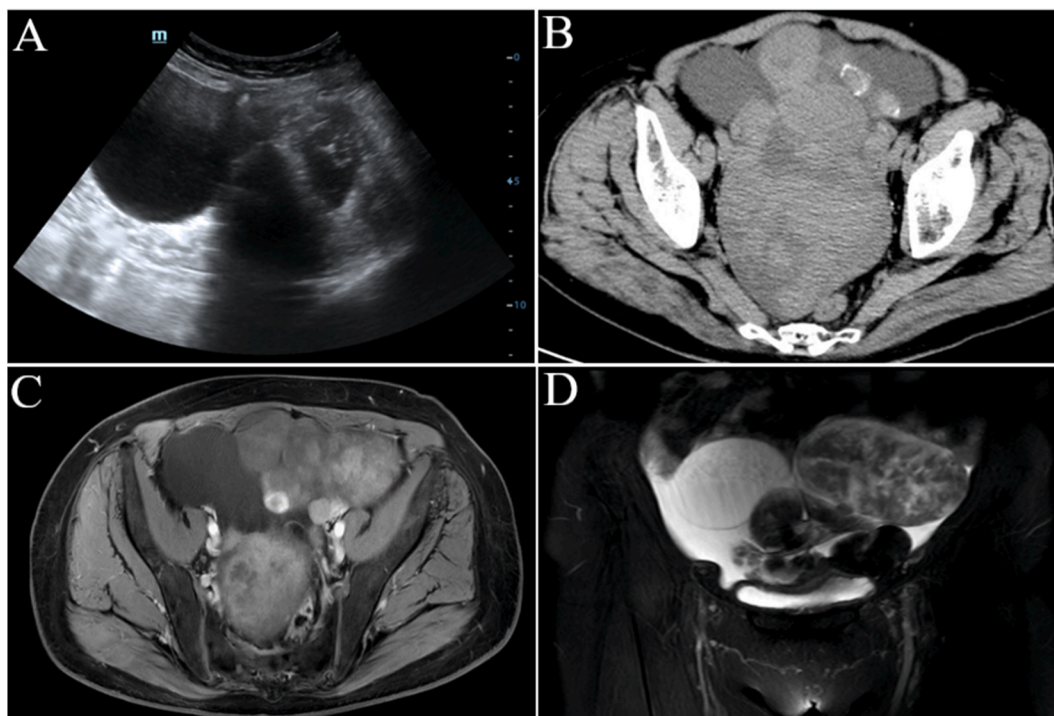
Imaging. Ultrasound revealed multiple low-echo and cystic solid masses of different sizes in the pelvic cavity, with clear boundaries and uneven internal echo. The largest one was 14.2cm × 8.3cm × 6.9cm (A). CT showed multiple solid masses in the lower abdomen and pelvis, some of which were cystic, with uneven density and clear boundary (B). MRI examination of the uterine adnexa showed equal or slightly longer T1 and low or super long T2 mixed multiple clumps signal shadow, mild uneven delayed enhancement in the solid part and no obvious enhancement in the cystic component (C, D).
